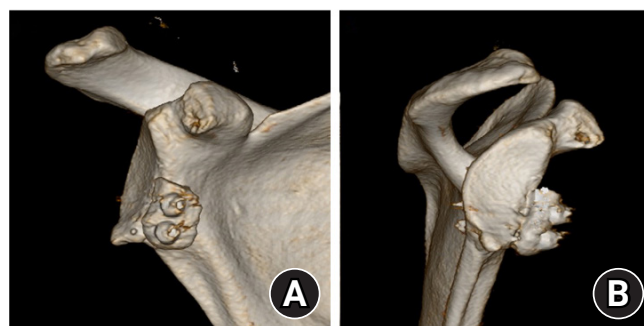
Postoperative three-dimensional computed tomography after arthroscopic Latarjet procedure of right shoulder. (A) The transferred coracoid process forms proper congruency with the existing glenoid articular surface. (B) The coracoid process was well-fixed at the appropriate height in the enface view.
